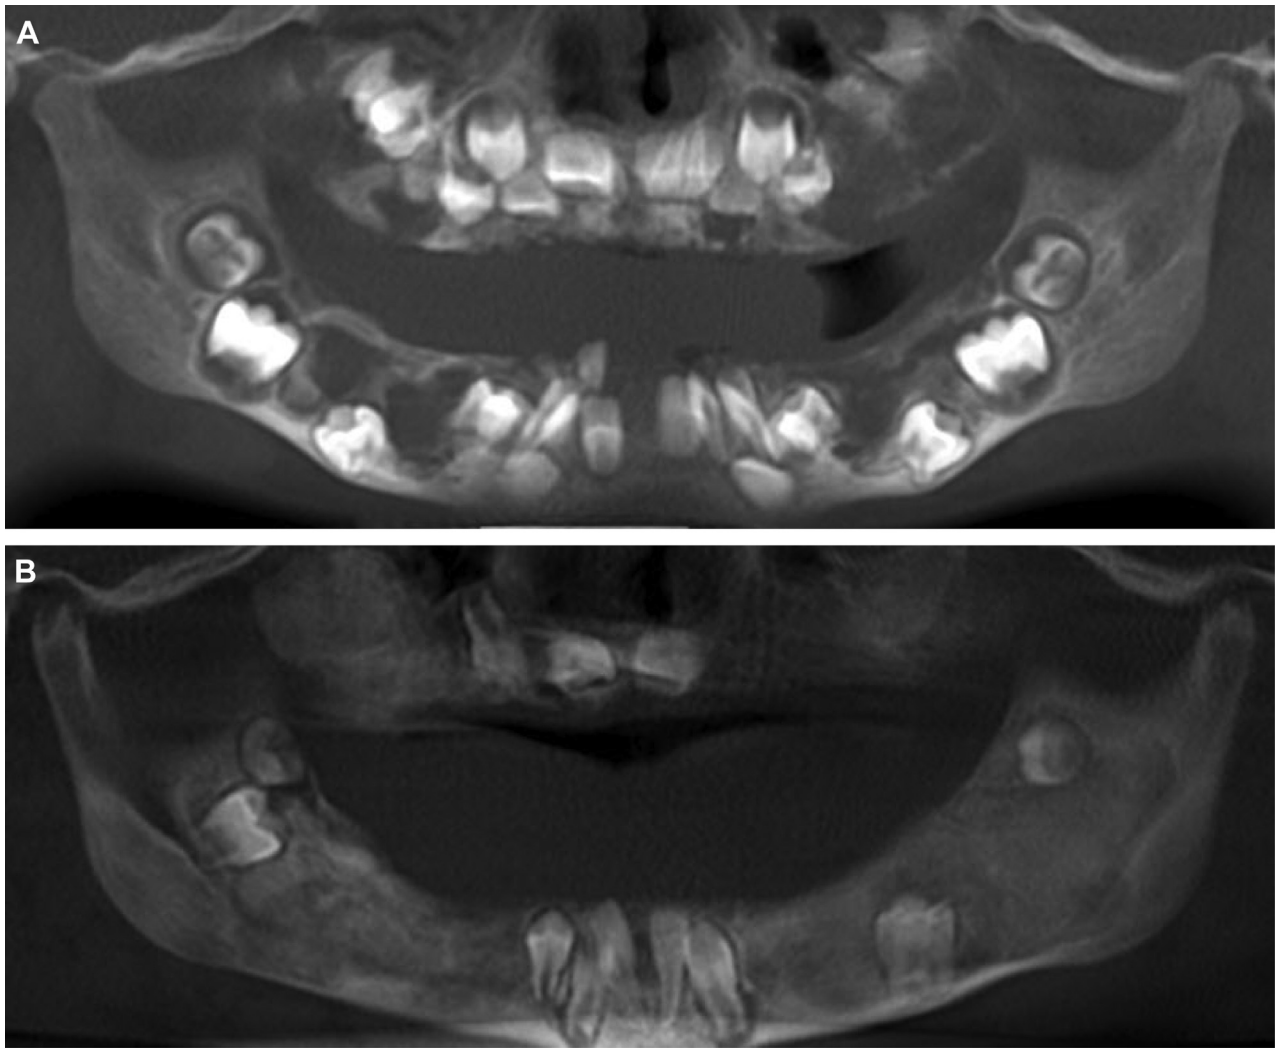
True-Pan cone-beam computed tomograms A, before and B, after 15 doses of denosumab.
